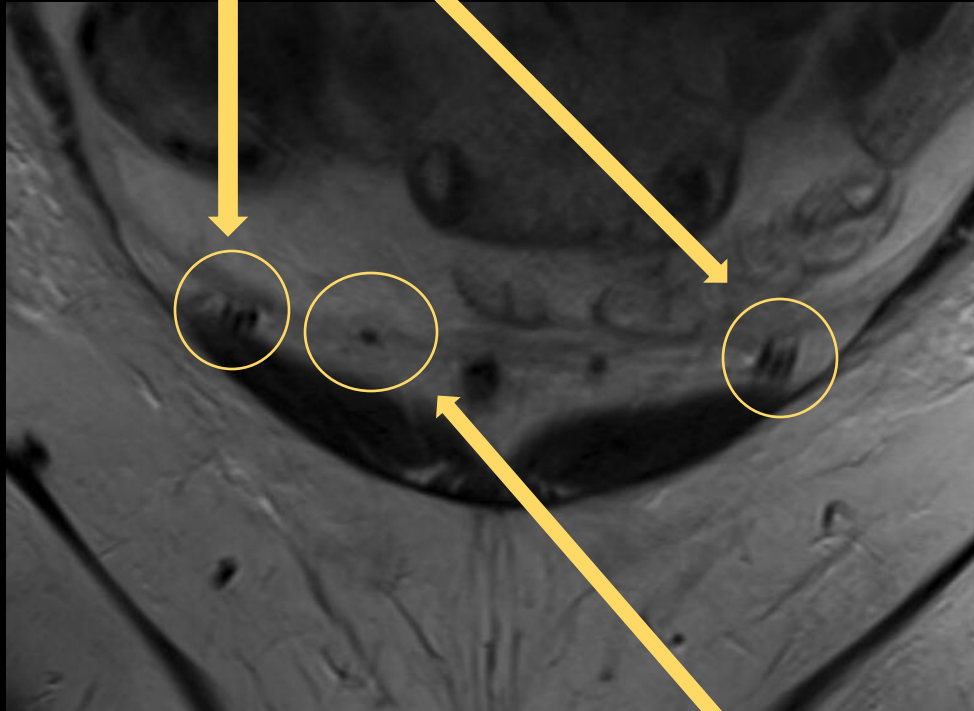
MRI pelvis (labeled)
